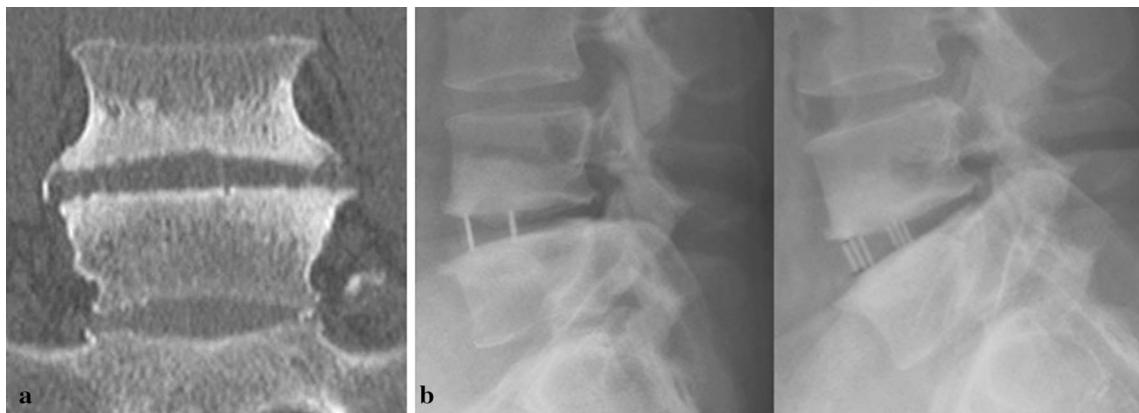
a Reconstructed CT scan showing the progression of bony union on the lateral side of the L4–5 intervertebral disc space and b plain radiographs showing the intervertebral range of motion had almost disappeared
